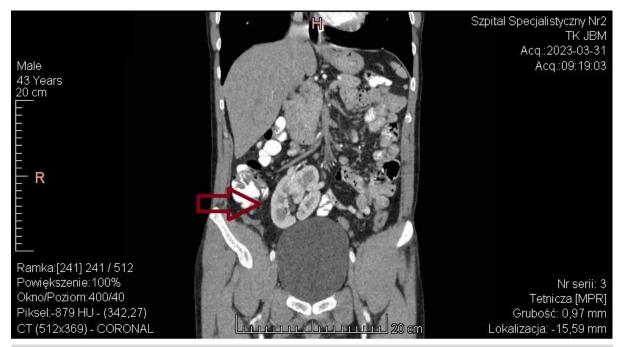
Image reconstruction from a contrast-enhanced CT scan of abdomen and small pelvis in arterial phase. Ectopic right kidney is marked with arrow.
